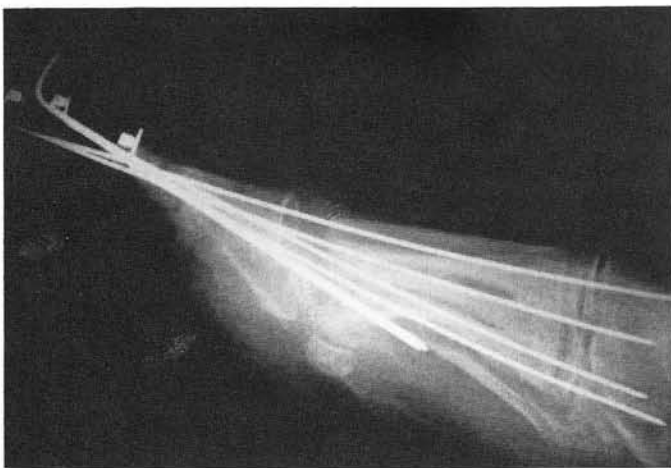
Postoperative lateral x-ray.
